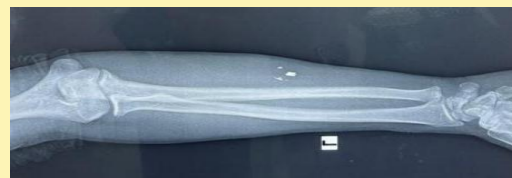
Pre-operative plain radiograph showing retained foreign body
